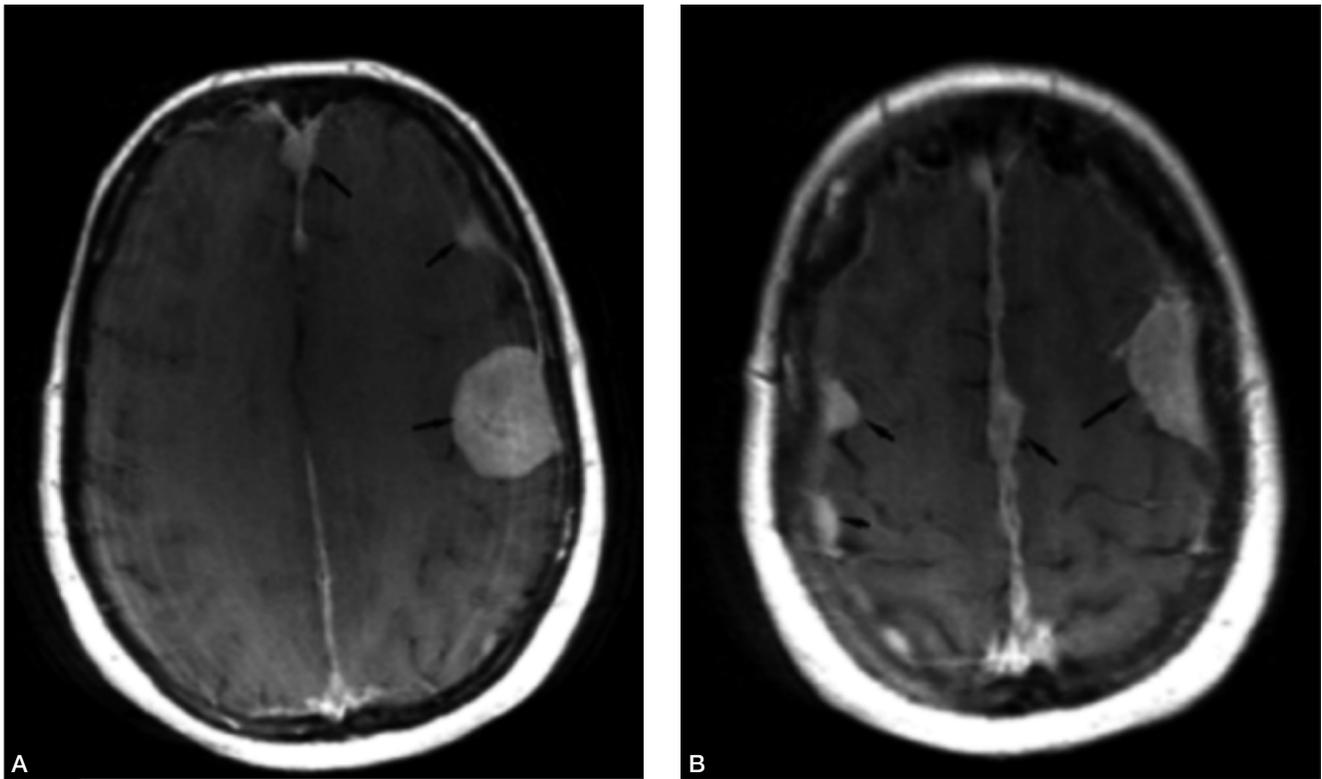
Axial T1-weighted contrast enhanced (gadolinium) (A-B) magnetic resonance images of the brain showing multiple meningiomas as hyperintense lesions (“meningiomatosis”).
